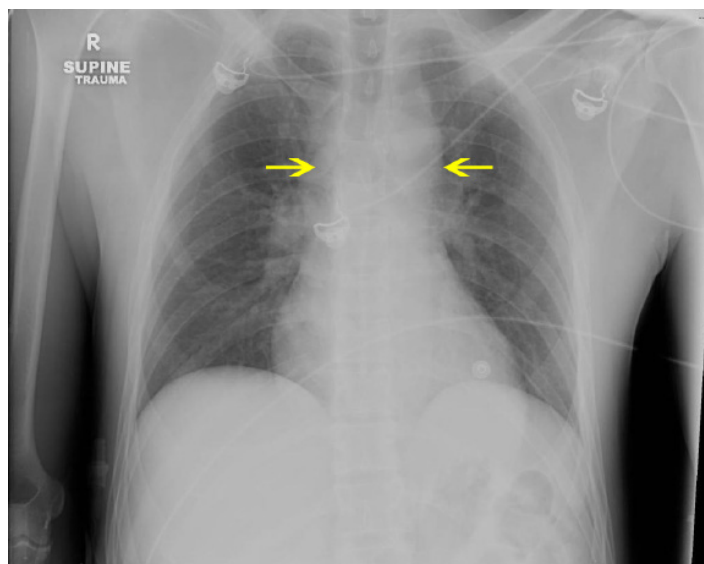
Chest radiograph demonstrating a widened upper mediastinum.
